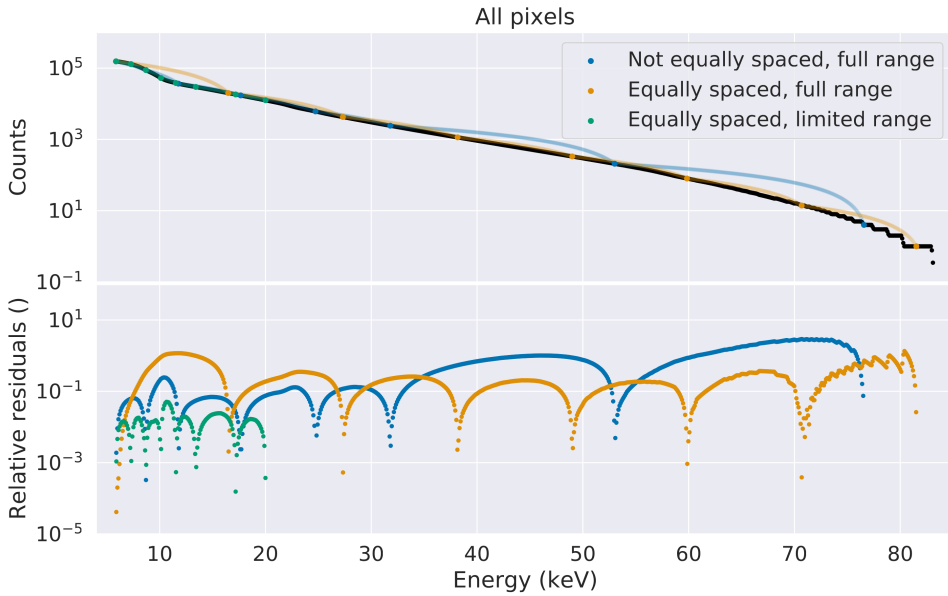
The counts as a function of energy for a high energy resolution scan for all pixels in this Si detector with three approaches for ECI in terms of threshold spacing and their respective relative residuals. A Si detector was used with a x-ray tube voltage of 90 kVp and only air (flat-field) was measured.
